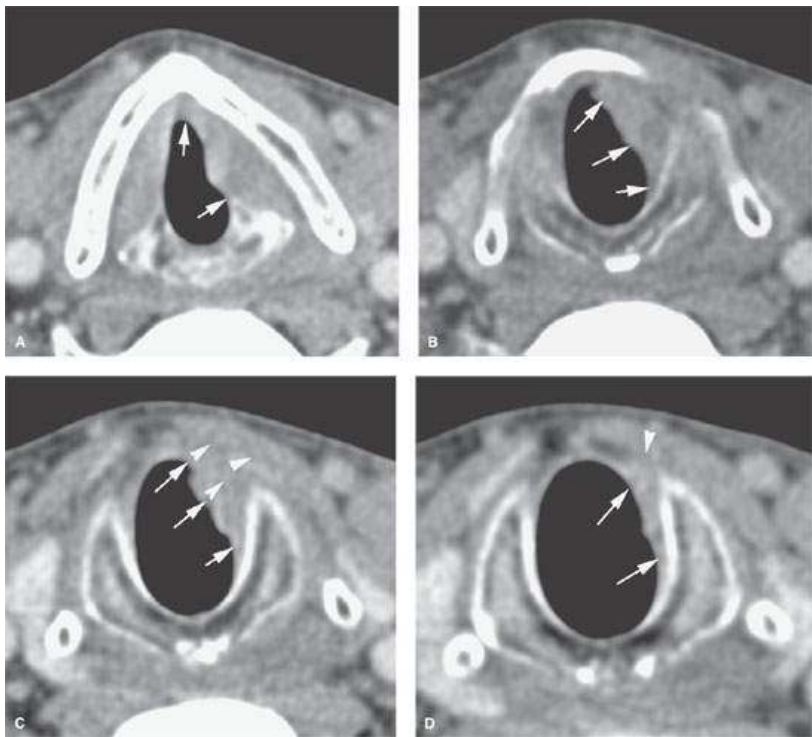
A patient presenting with what was believed to be true vocal cord paralysis. Computed tomography study from the posterior fossa to the aortopulmonary window showed no abnormality along the vagus or recurrent laryngeal nerves. It did, however, show an infiltrating tumor of the larynx that was entirely submucosal. A: The tumor involves the entire true cord up to the anterior commissure (arrows). B: Subglottic spread is present (arrows). C: The subglottic spread (arrows) extends through the cricothyroid membrane into the soft tissues beneath the infrahyoid strap muscles (arrowheads). D: Continued subglottic spread is present almost to the bottom of the cricoid cartilage (arrows).
